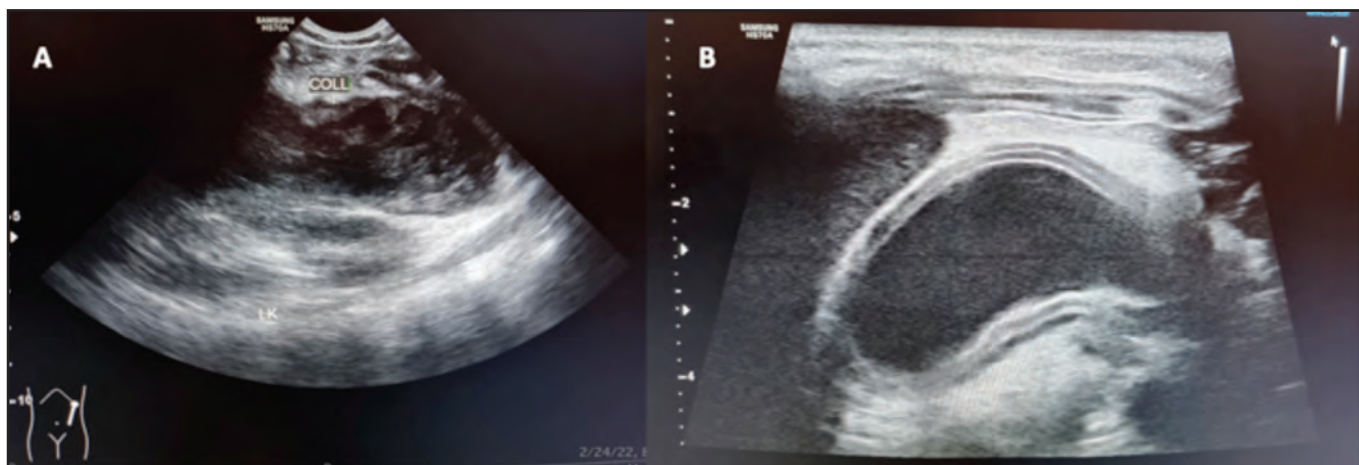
Initial ultrasound showed heterogenous hypoechoic collection in the left retroperitoneal region (A). Targeted relook ultrasound showed a cystic lesion with the gut signature sign, with echogenic mucosa and hypoechoic muscularis propria, relatively specific for duplication cyst (B).
